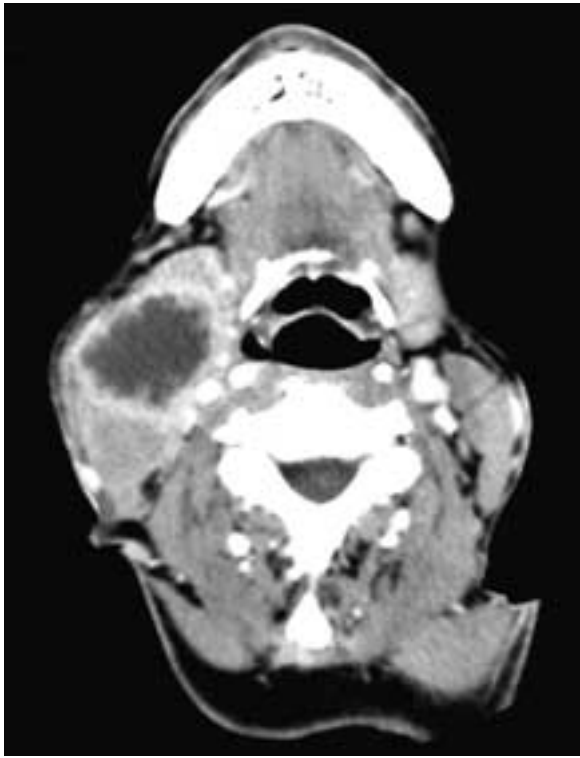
Axial contrast-enhanced CT scan shows a large right level II node with a highly nodular enhancing rim and slight infiltration of the adjacent tissues. The nodularity of the wall differentiates this metastatic squamous cell carcinoma node from a cyst.
